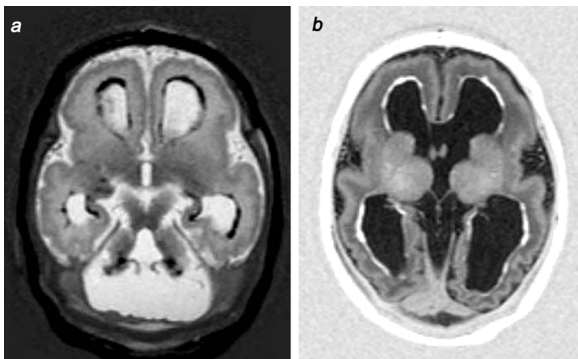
MRI, axial T1- [A] and T2- [B] weighted sequence showing ventricular dilatation and cerebellar hypoplasia. Periventricular calcification is seen as increased signal intensity on T1 and low signal intensity on the T2-weighted images. Extensive polymicrogyria is seen as well.
